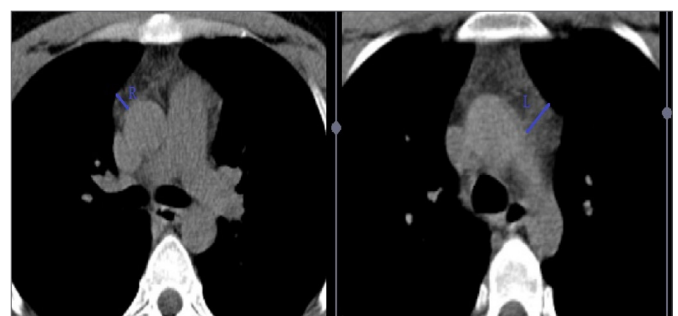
The axial CT image with the largest area of thymic lobe was selected for measuring the thickness of each lobes.
